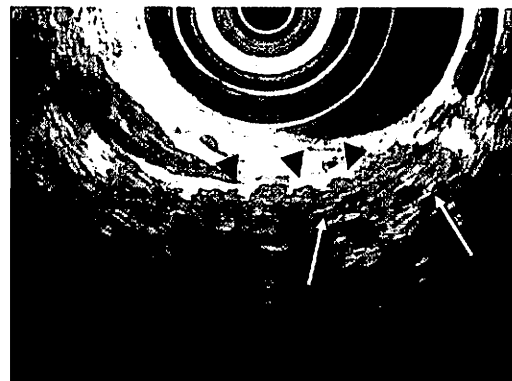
Endoscopic ultrasonography showing hyperechoic foci (arrow) and hyperechoic duct margins (arrowhead).
